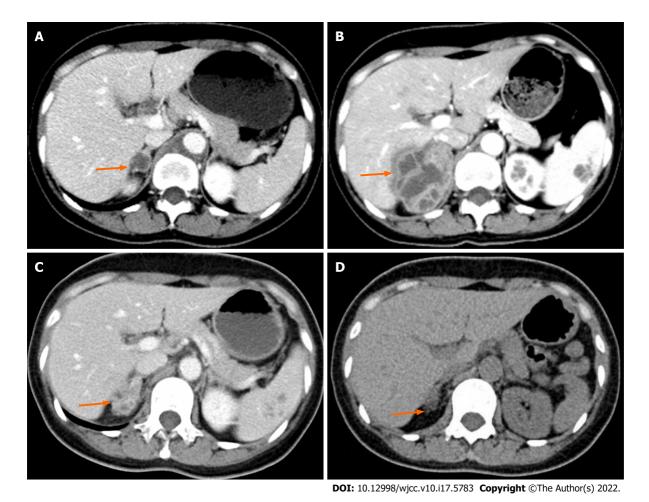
These were contrast-enhanced axial computed tomography images of the abdomen. A: Showed an isointense mass of 1.5 cm in the right adrenal gland; B: Showed an irregular mass of 6.0 cm × 4.5 cm with uneven density (20-30 HU in the central and 80-90 HU in the peripheral) in the right adrenal gland, while the left one was normal; C: Showed that the mass became smaller (2.7 cm × 2.4 cm) after anti-TB therapy for a total of 15 mo; D: Showed a slight enlargement of the right adrenal gland after about three years' anti-TB therapy.
